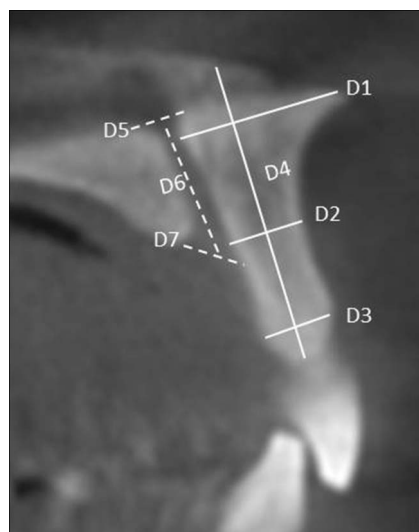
Measurements of anatomical structures in sagittal sections from the cone beam computed tomography image. Ridge width anterior to the canal; (D1) apical, (D2) middle, (D3) crestal, (D4) the length of buccal residual bone, (D5) the diameter of the nasopalatine foramen, (D6) the length of the nasopalatine canal, and (D7) the diameter of the incisive foramen.
